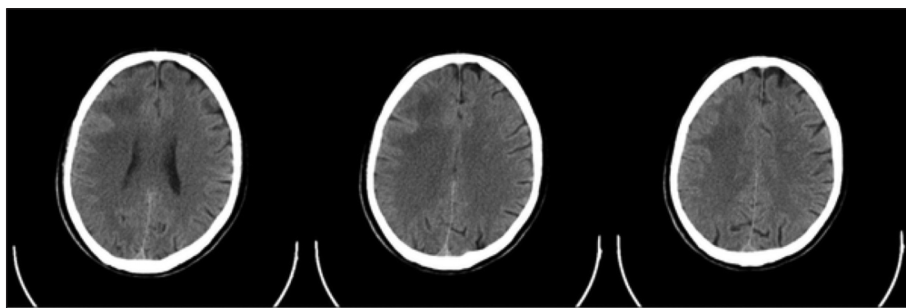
Cranial CT: A right frontal lobe localised hypodense lesion.
